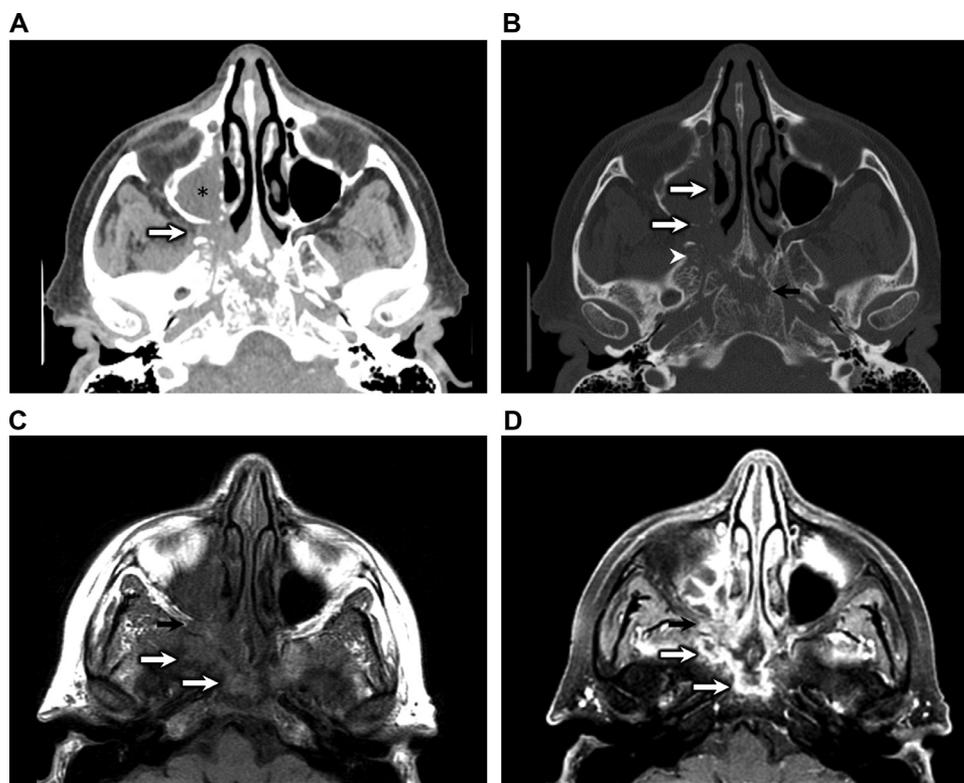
(A) Surgically proven mucormycosis involving the pterygopalatine fossa. (A,B) Axial CT without contrast. (A) There is abnormal soft tissue effacing the right pterygopalatine fossa (white arrow) with adjacent complete opacification of the right maxillary sinus (black asterisk). (B) Bone windows demonstrate areas of subtle erosion along the right maxillary sinus (white arrows), involving the right pterygoid process (white arrowhead) and the clivus (black arrow), indicating an aggressive process. (C) Axial T1-weighted image confirms abnormal central skull base T1-hypointense marrow (white arrows) and soft tissue in the right pterygopalatine fossa (black arrow) which on (D) axial T1-weighted postcontrast fat-saturated image demonstrates abnormal enhancement, respectively. Endoscopic surgery confirmed suspected invasive fungal sinusitis in this 60-year-old female acutely ill bone marrow transplant patient.
